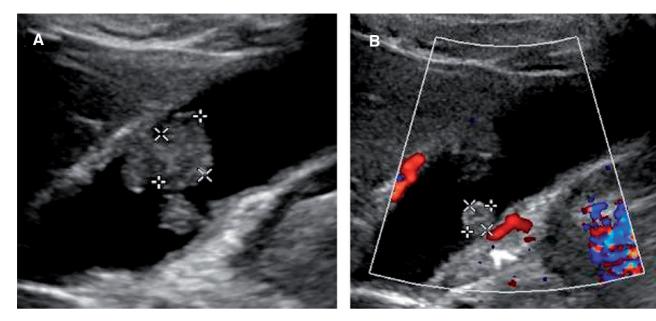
Abdominal right upper quadrant ultrasound showing (A) greyscale image of a hyperechoic lesion without acoustic shadowing within gallbladder lumen, suggestive of gallbladder polyp (inside crosshairs) measuring $1.5 \times 1.2 \, \text{cm}$, and (B) color Doppler image of a separate gallbladder polyp, measuring $0.7 \times 0.6 \, \text{cm}$. Images obtained with curved transducer.
